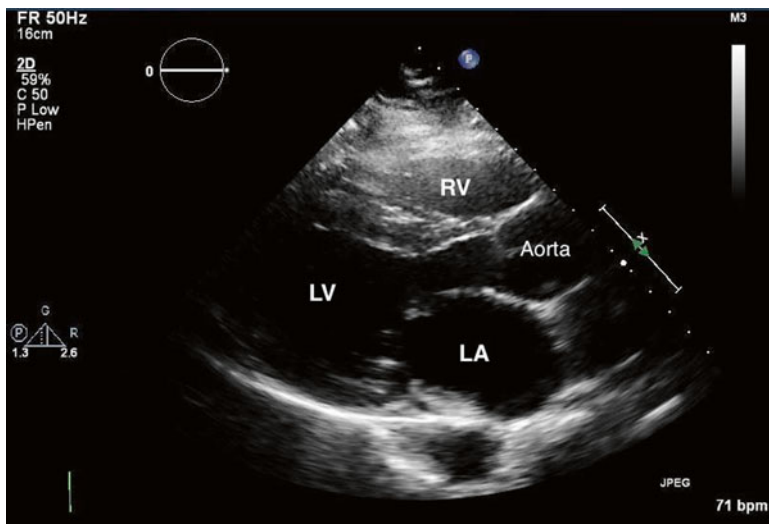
Parasternal long-axis view. Visualization of the right ventricle (RV) superiorly, the left ventricle inferiorly, with the left atrium (LA) and the base or root of the aorta (aorta) on the left of the viewing screen. Also visualized are the left sided heart valves, i.e., the mitral and aortic valves
